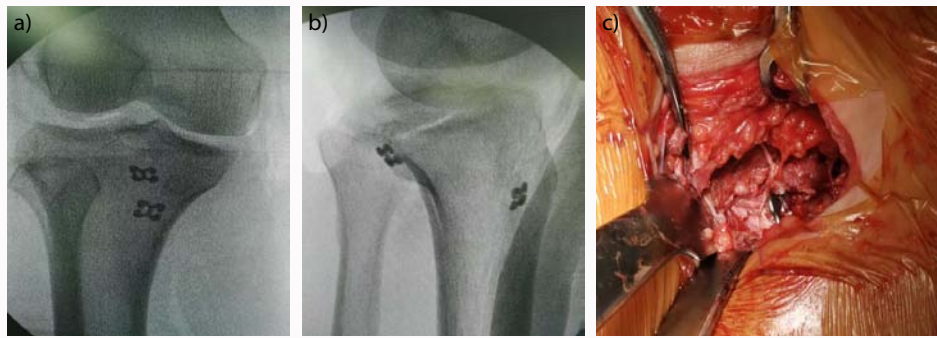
Intraoperative radiograph of double button plate fixation. a, b) intraoperative X-ray showed that the fracture was well reduced and fixed, C) showed the titanium plate passed bone canal and position was acceptable.
